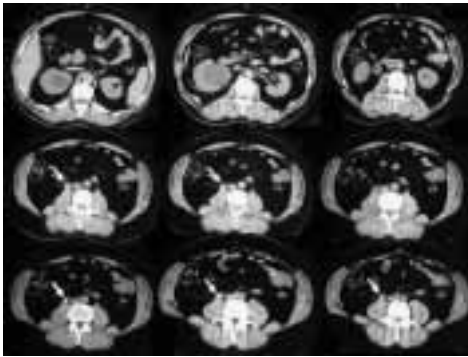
Computed tomography without contrast injection. Right hydronephrosis as well as small calculi in the left kidney (B). Radioopaque lesions (white arrows) in ureteral lumen associated with periureteral inflammation are seen.
